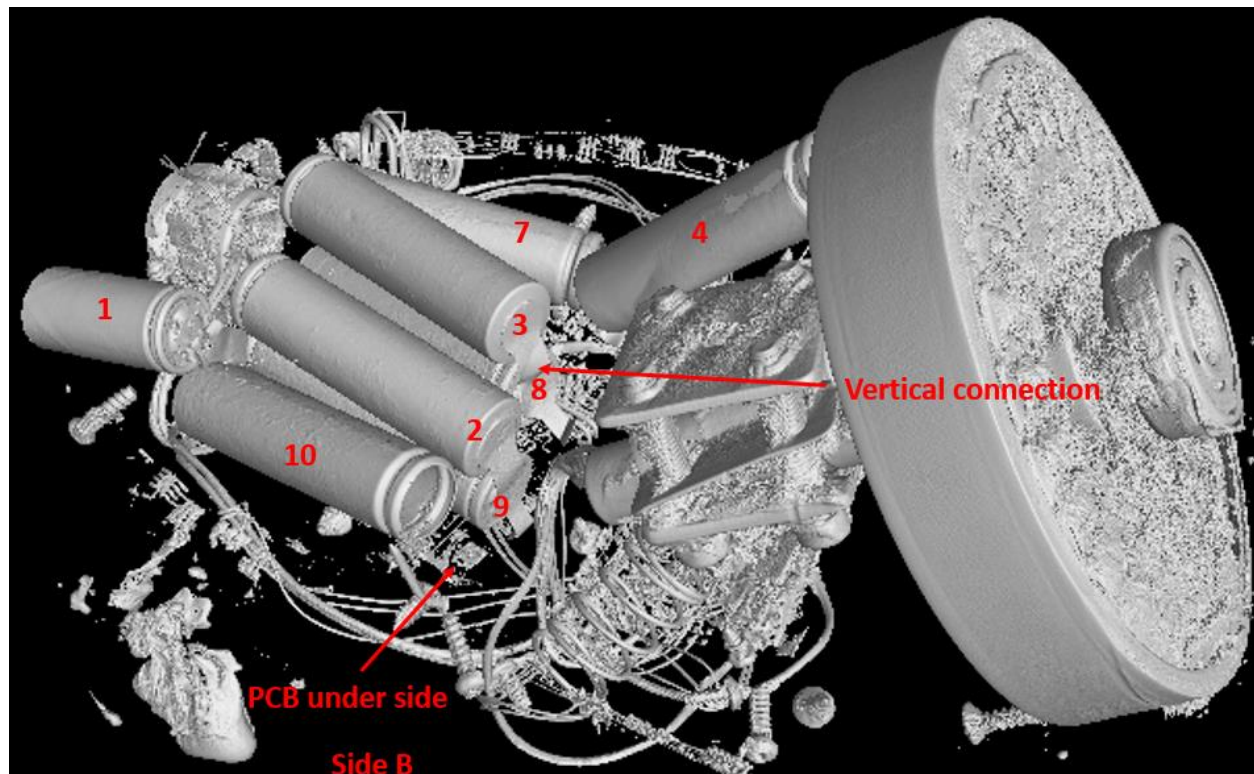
An example of using CT scan data to identify evidence cells' original positions.
